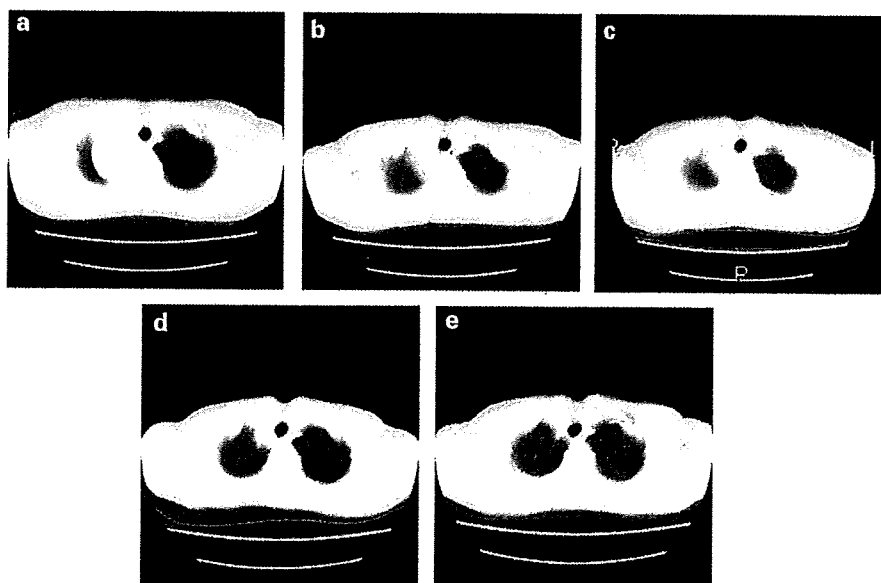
(a) Computed tomography (CT) images of a primitive neuroectodermal tumor in the apical lesion on relapse after autoperipheral blood SCT. (b) After four courses of chemotherapy, the patient achieved partial remission. A CT scan taken 1 month after the allogeneic SCT, the tumor size was almost no change (c), but 4 months after, it showed 50% reduction of the apical tumor (d). CR was confirmed at 8 months (e).
